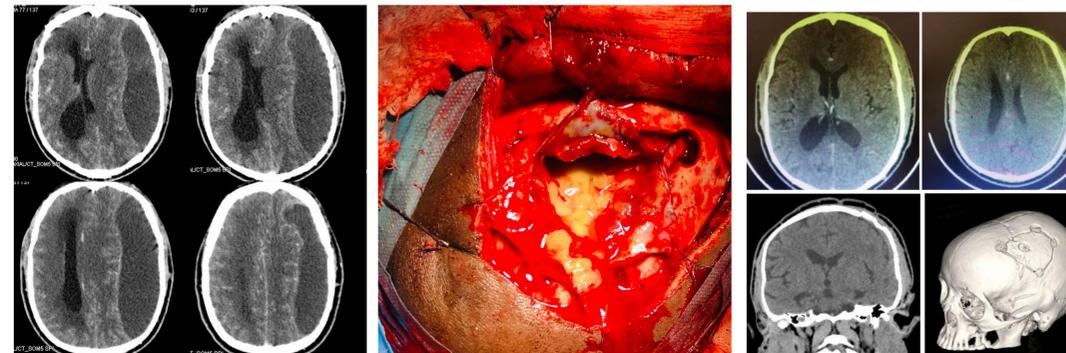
Pre-operative CT brain with contrast showing a subdural empyema as a left-sided hypodense collection with significant mass effect on the ipsilateral ventricle and midline shift. The periphery enhances after contrast.
